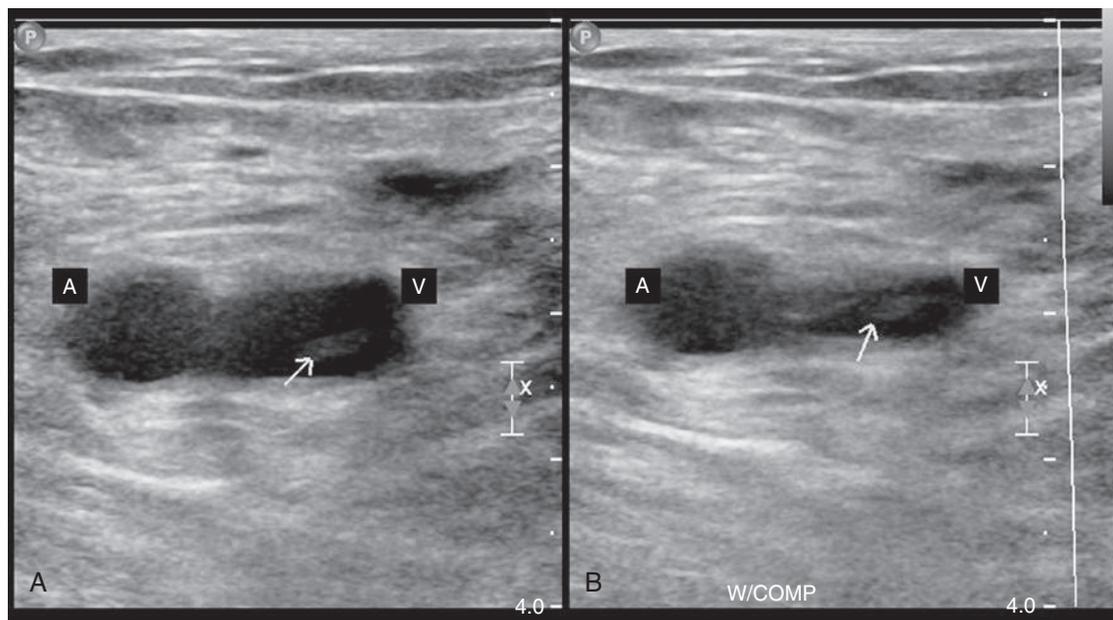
Deep vein thrombosis diagnosed by ultrasonography. A, An intraluminal thrombus is visible in the right common femoral vein (arrow). B Incomplete collapse of the femoral vein secondary to the presence of a clot. A, Femoral artery; V, femoral vein.
